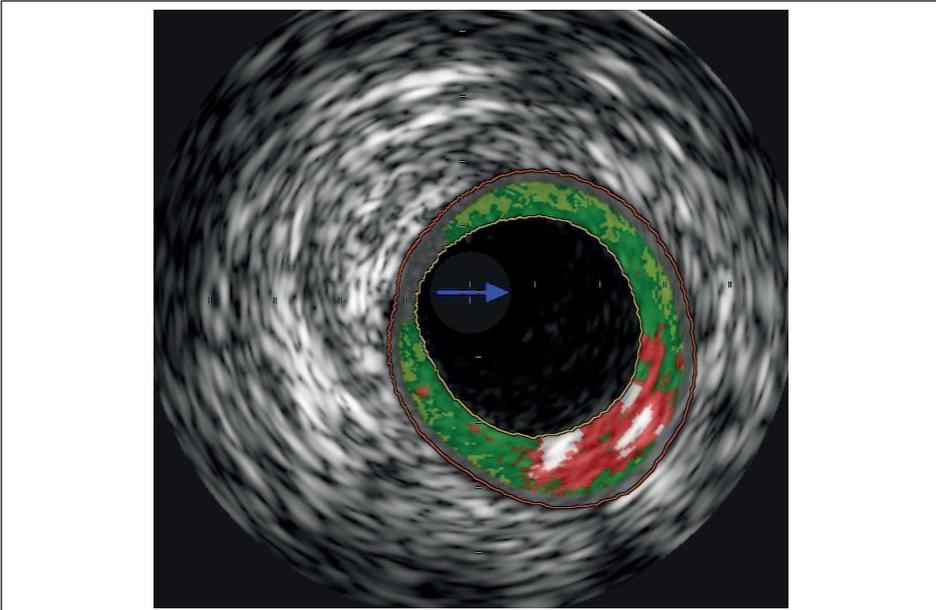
Thin-cap fibroatheroma as classified by radiofrequency intravascular ultrasonography
